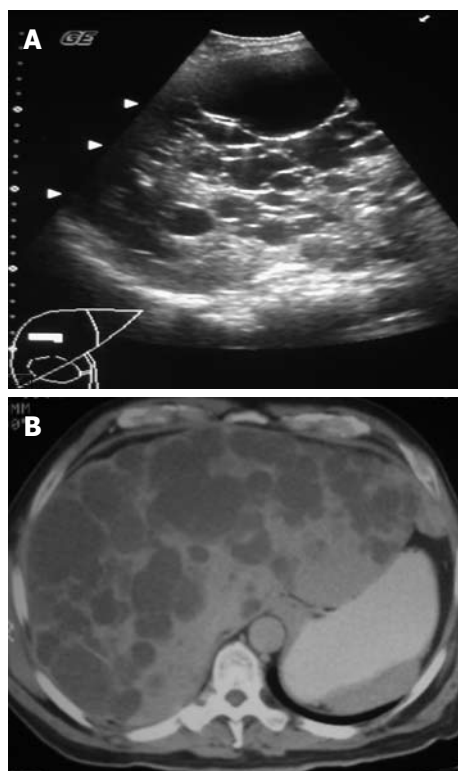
US (A) and CT (B) images showing numerous hepatic cysts in a 47-year-old asymptomatic male patient.
